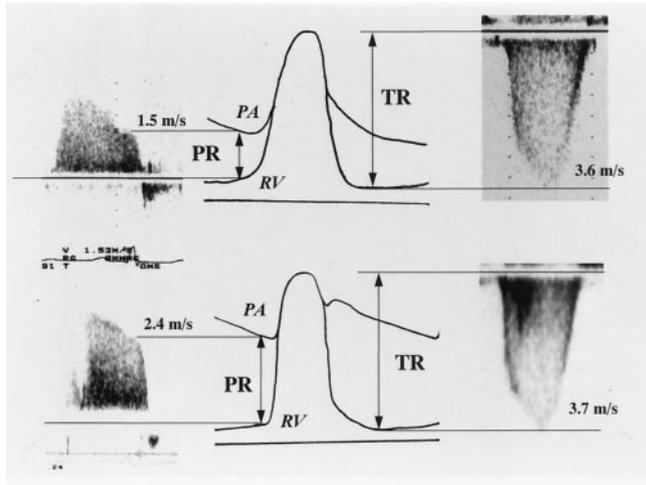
Continuous Doppler measurements in representative cases with the scheme of PA and RV pressure waveforms (center). The top panels are from a patient with CPTe. The bottom panels are from a patient with PPH. The right panels are the continuous Doppler measurements of TR. The left panels are the continuous Doppler measurements of PR. Although the Doppler flow velocities of TR are comparable between CPTe and PPH, those of PR are lower in CPTe than in PPH. The peak pressure gradient (TR) across the tricuspid valve during systole is defined as a measure of PA systolic pressure. We also approximated diastolic pressure (PR) from the velocity of PR flow at the moment of its abrupt deceleration in late diastole. If the abrupt deceleration was not identifiable, we approximated it from PR flow at the moment of the R wave.
